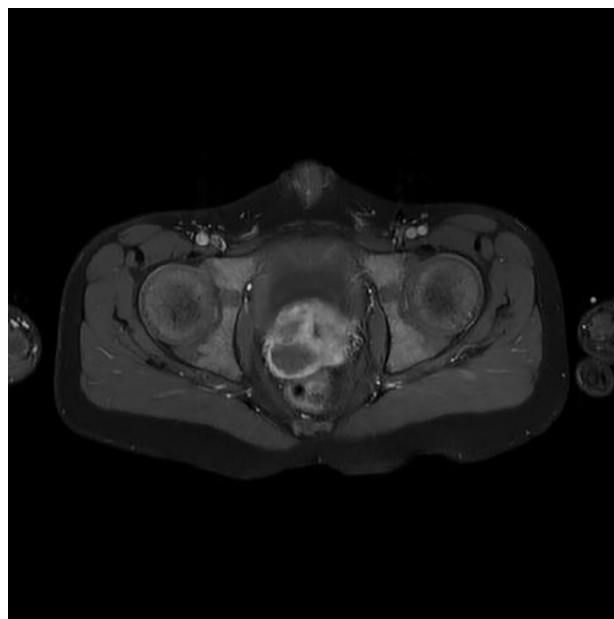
Magnetic resonance imaging of the third disease recurrence (contrast-enhanced axial T1 water-only sequence).
